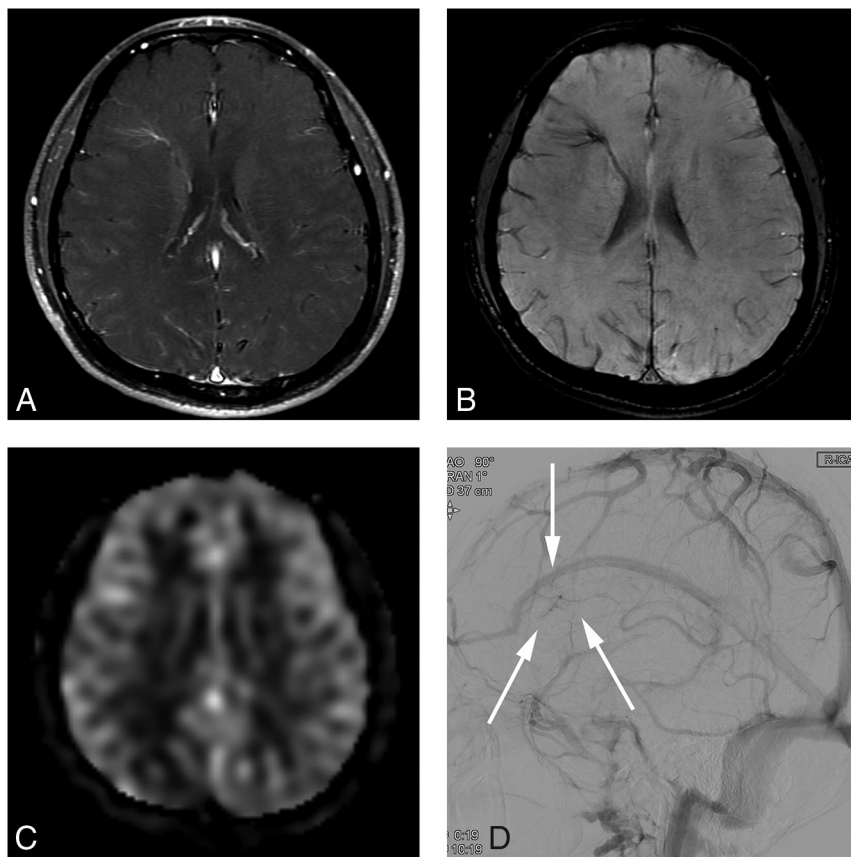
A 29-year-old man presenting with an AVM in the left occipital lobe (case 11). *A*, Contrast-enhanced T1-weighted axial MR imaging shows a DVA-like lesion in the right frontal lobe. *B*, SWI shows hypointense signal in the lesion. *C*, An ASL quantitative CBF image demonstrates no identifiable signal corresponding to the lesion. *D*, On DSA, the lesion is first visualized in the late venous phase (arrows), as is typically seen in a classic DVA.
